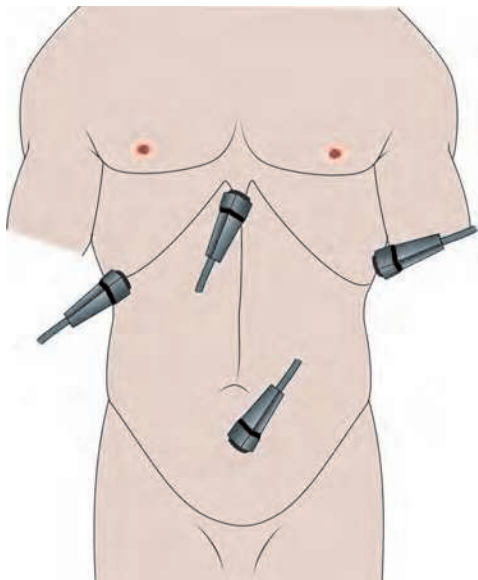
Site of probe placement for focussed assessment sonography in trauma (FAST) examination. The probe locations for FAST views are right upper quadrant, left upper quadrant, pericardial space and pelvis
